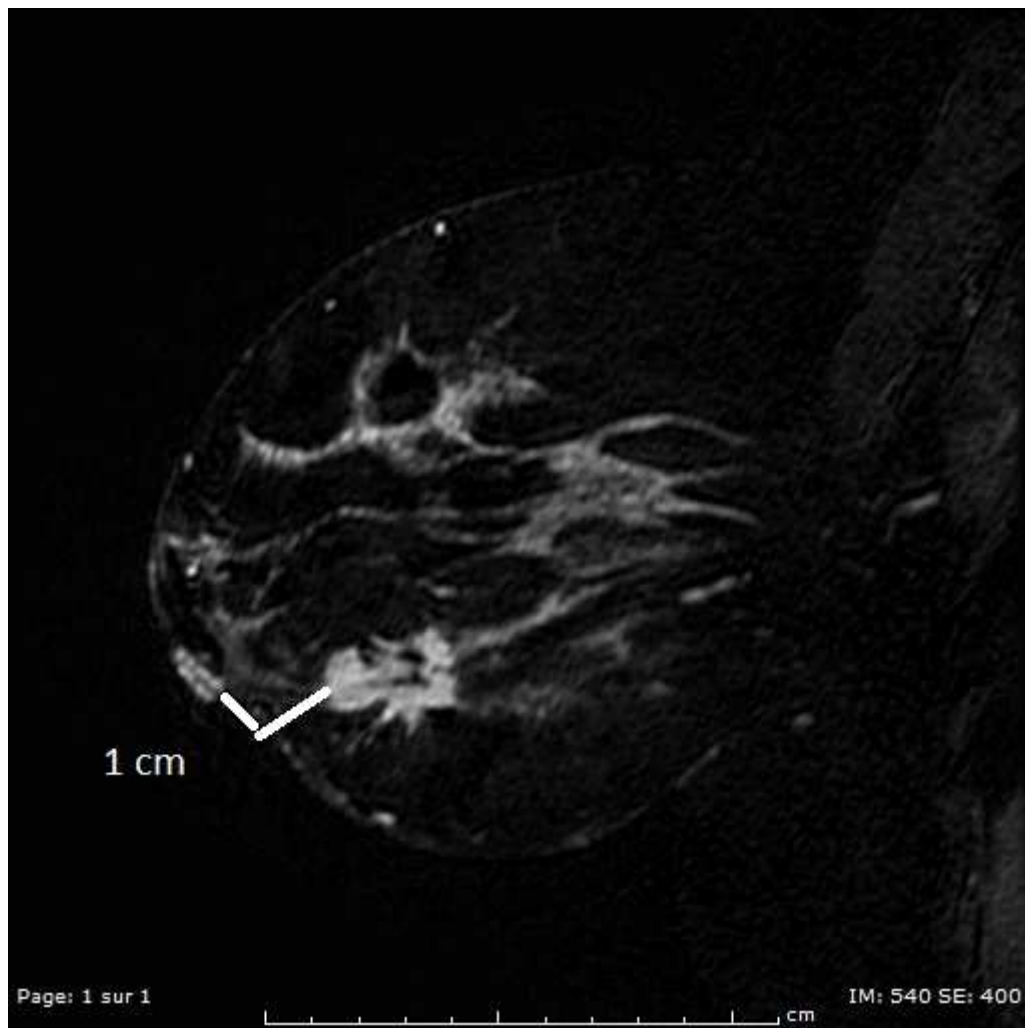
breast carcinoma on US and MRI
